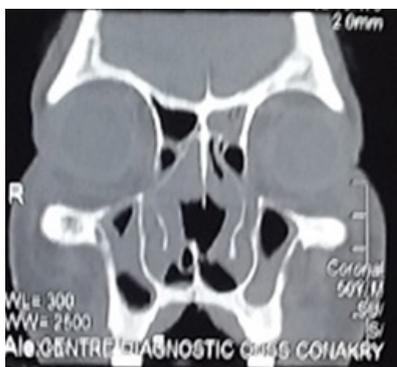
The CT scan of isodensity of the maxillary, ethmoidal and left sphenoidal sinus walls without total filling.
